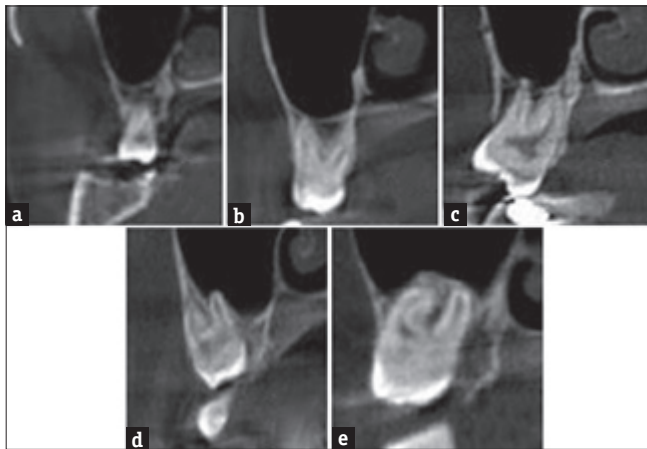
Cone-beam computed tomography images of the maxillary third molars according to the vertical relationships between the roots of the maxillary third molars and maxillary sinus floor: (a) Type I, (b) Type II, (c) Type III, (d) Type IV, (e) Type V
